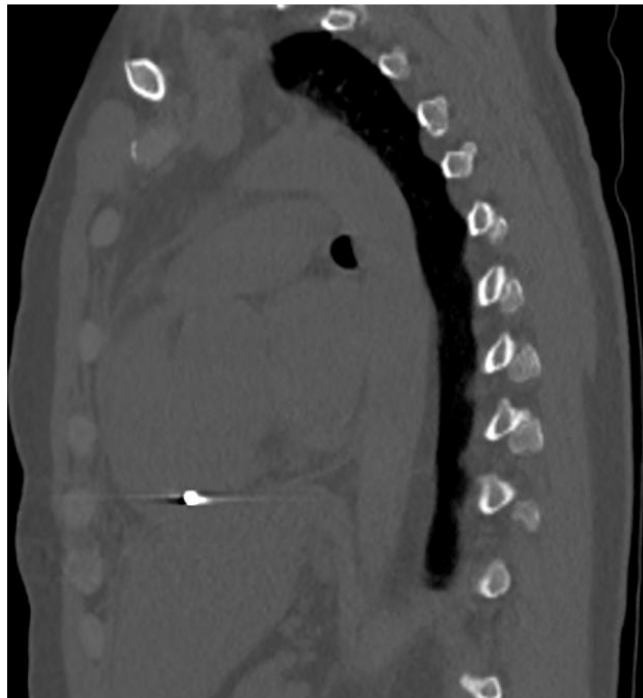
Spiral CT of chest organs: a metal fragment in the wall of the right ventricle of the heart. A – axial plane; B – coronary plane; B – sagittal plane.
